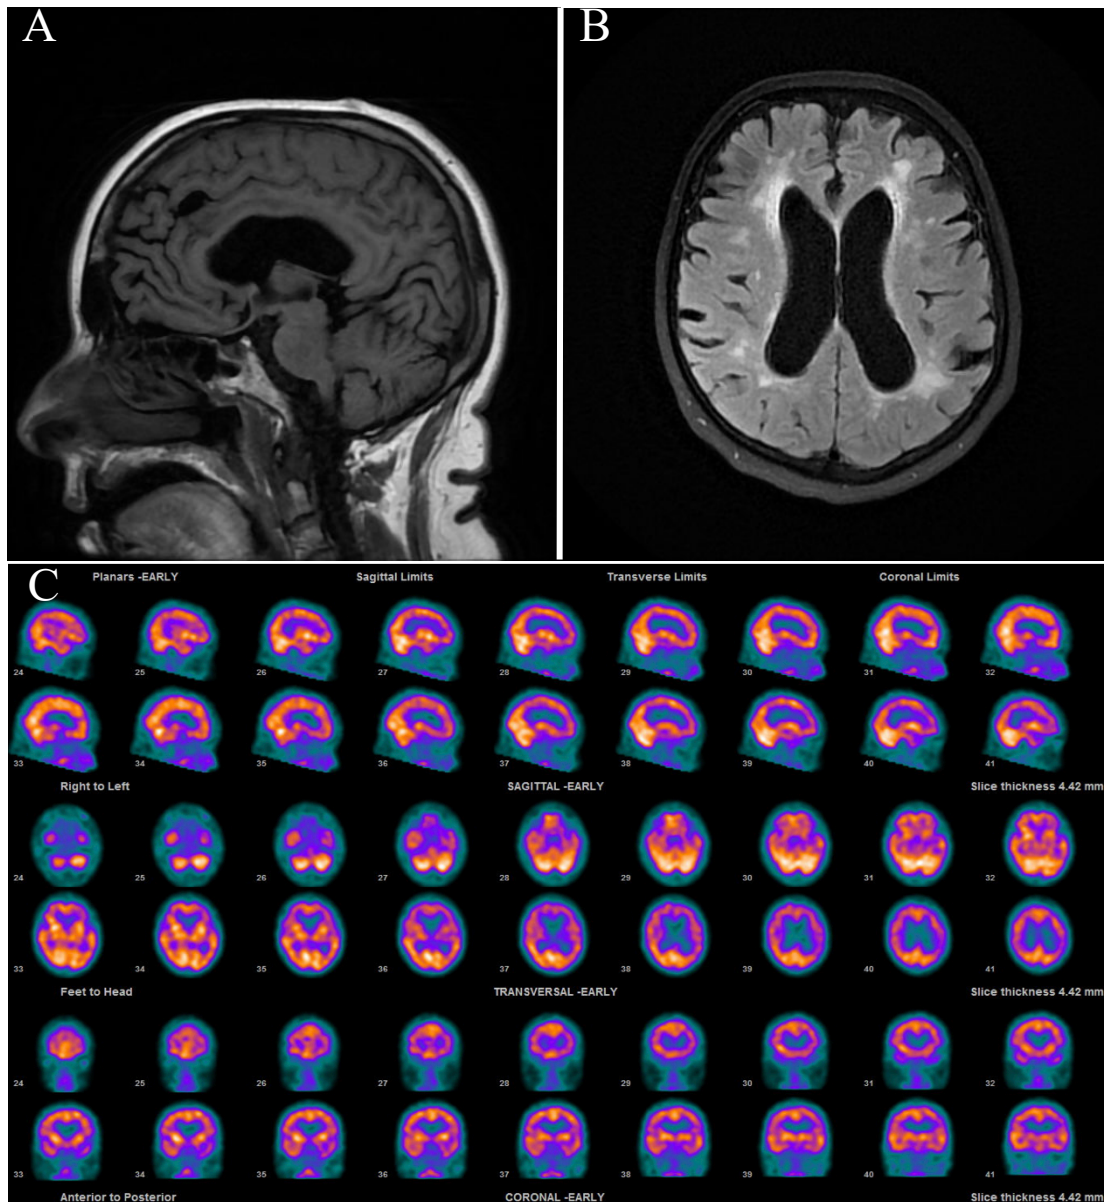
Magnetic resonance images (MRI) and SPECT images of the brain, demonstrating diffuse brain atrophy and small vessel ischemia. (A) T1 Flair sagittal MRI; (B) T2 Flair axial MRI; (C) SPECT brain perfusion imaging.
